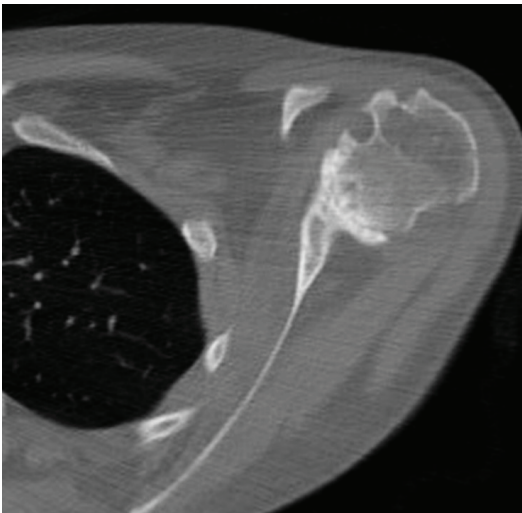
Computed tomography (axial view) of the left shoulder showing type 3 glenoid defect according to modified Walch classification.
